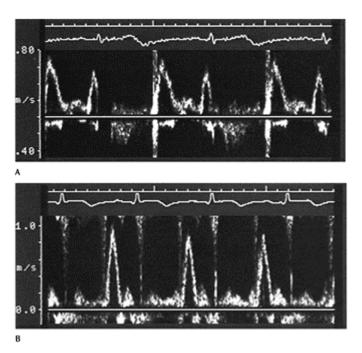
Examples of normal (or pseudonormal) pattern (A) and restrictive pattern (B) of transmitral flow assessed by pulsed-wave Doppler immediately after admission to coronary care unit.
